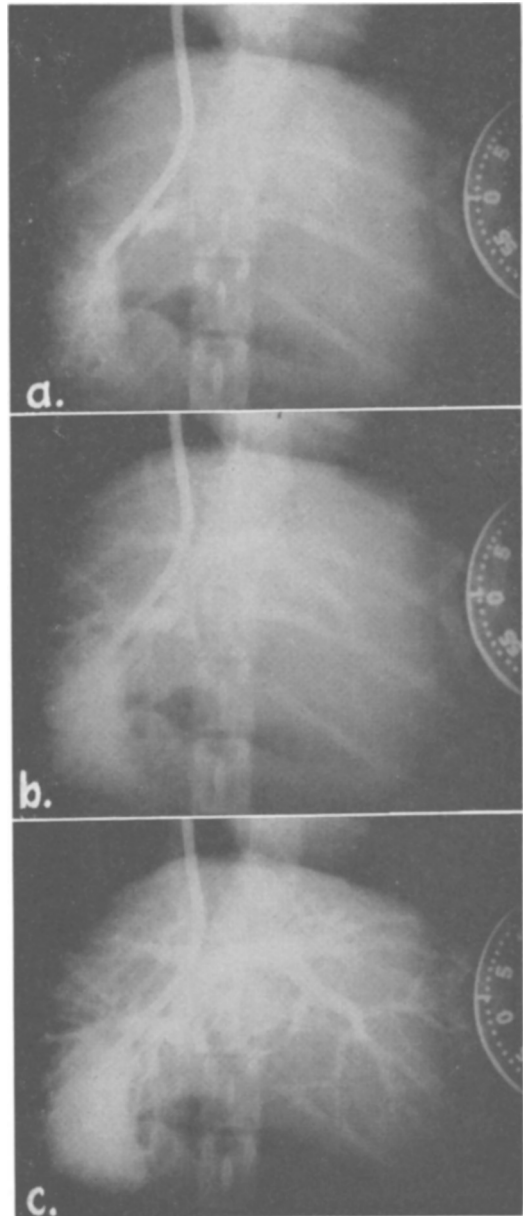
a, b, c. Serial x-rays; note filling of sinusoids at catheter tip followed by progressive filling of the portal venous bed. (#25)
